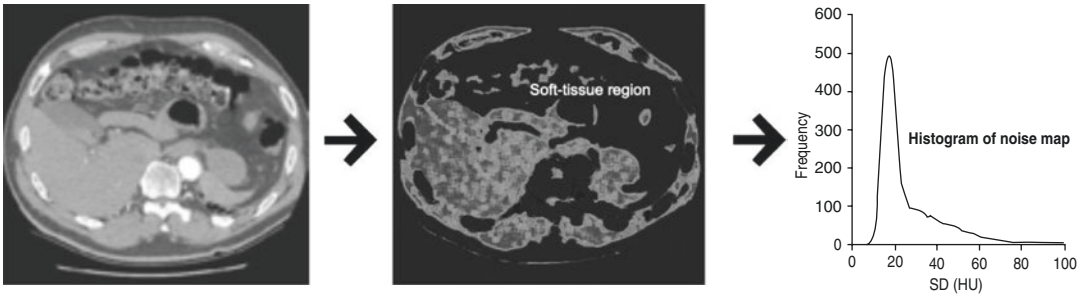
Noise magnitude estimation process. Original CT images (left), noise map showing soft-tissue region (middle), and histogram of noise map for soft-tissue regions (right) [19]
